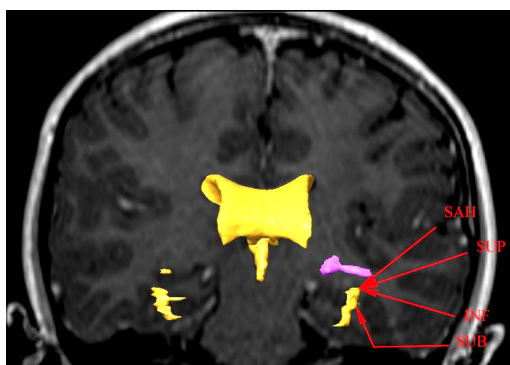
Surgical approaches-relationship between Meyer's loop and the temporal horn. Coronal T1-weighted MRI showing the relationship between Meyer's loop (in pink) and the temporal horn of the lateral ventricle (in yellow). The angles of approach to the temporal horn for: a SAH, TLR through the SUP, TLR through an INF, and the SUB. SAH, selective amygdalohippocampectomy; TLR, temporal lobe resection; SUP, superior temporal gyrus; INF, inferior approach; SUB, subtemporal approach.
